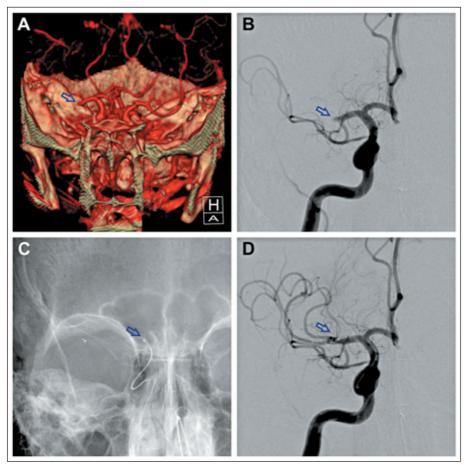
Acute stroke. (A) Occlusion of the M1 segment of the middle cerebral artery in the 3D-CT-angiography, (B) in the DSA. (C, D) "Stentriever" in position to capture the thrombus. After thrombus extraction complete recanalization of the middle cerebral artery is enabled.
